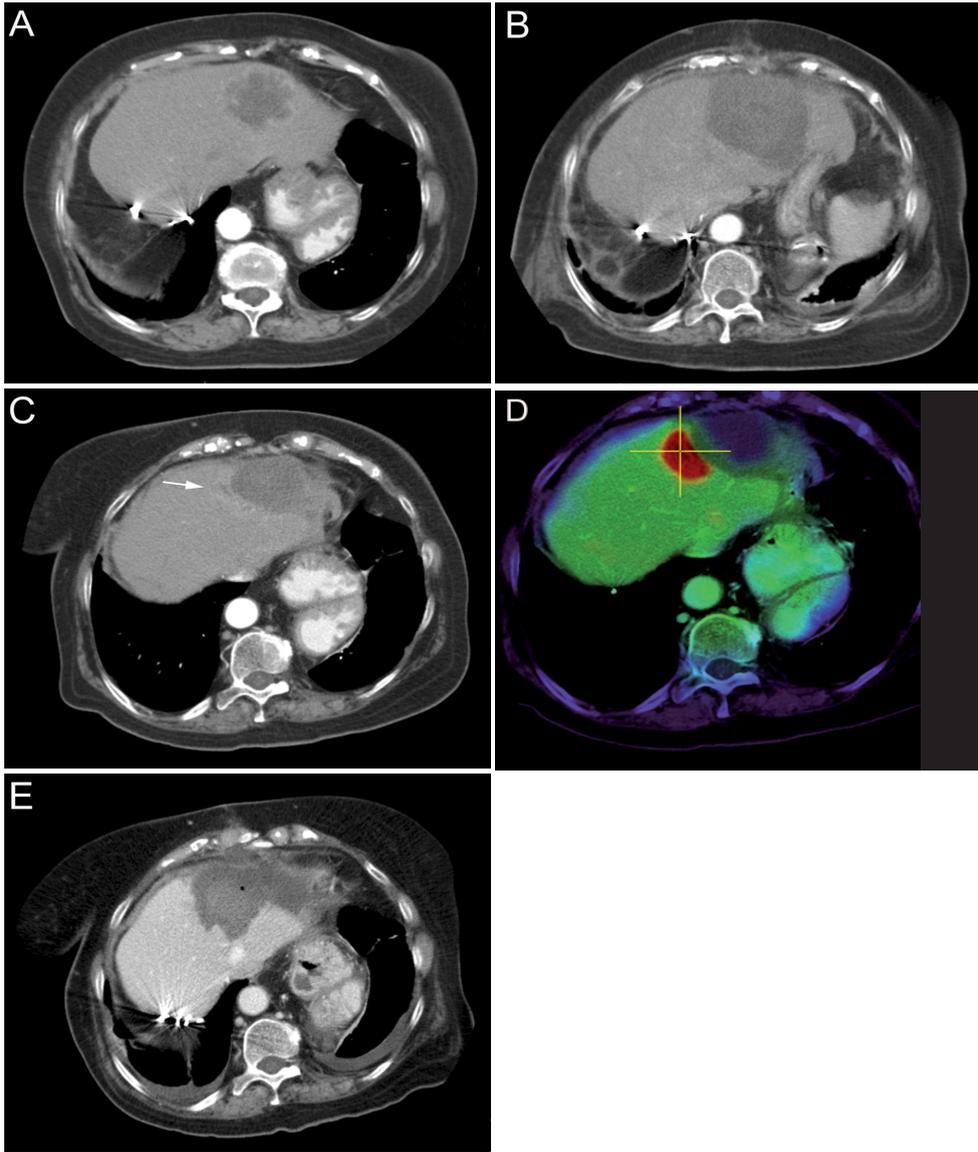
(A) Abdominal CT scan of a 76-year-old woman showing a colorectal liver metastases of 6.0 cm in diameter in segment IV, (B) CT scan two weeks post LITT demonstrating complete ablation with a coagulation lesion of 8.1 cm in diameter, (C) CT scan 6 months after LITT treatment demonstrating a rim of 0.9 cm recurrent tumor tissue on the medial site of the necrotic lesion (arrow), (D) Fusion scan of PET and CT scan 6 months after LITT demonstrating recurrent tumor tissue in the liver, (E) CT scan 5 days after second LITT treatment demonstrating complete ablation with a coagulation lesion of 8.6 cm in diameter.
